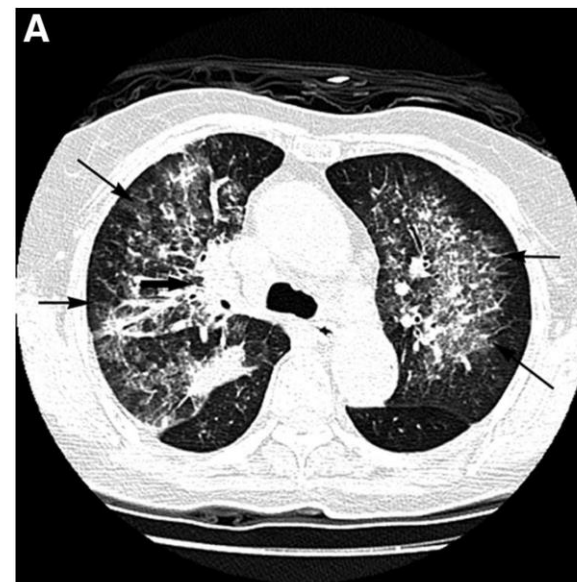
A, The chest computed tomography (CT) showed decreased size of the main tumor (*thick arrow*) and diffuse ground-glass opacity over upper lung zones (*thin arrows*) on the seventh week of gefitinib therapy. B, The chest CT performed on the 131th day of erlotinib therapy showed partial remission of right upper lung tumor (*arrow*).
